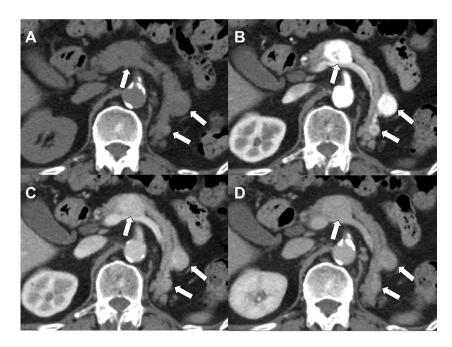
Computed tomography (CT). (A) Non–contrast-enhanced CT, (B) Contrast-enhanced CT, early arterial phase, (C) Contrast-enhanced CT, late arterial phase, (D) Contrast-enhanced CT, delayed phase.
